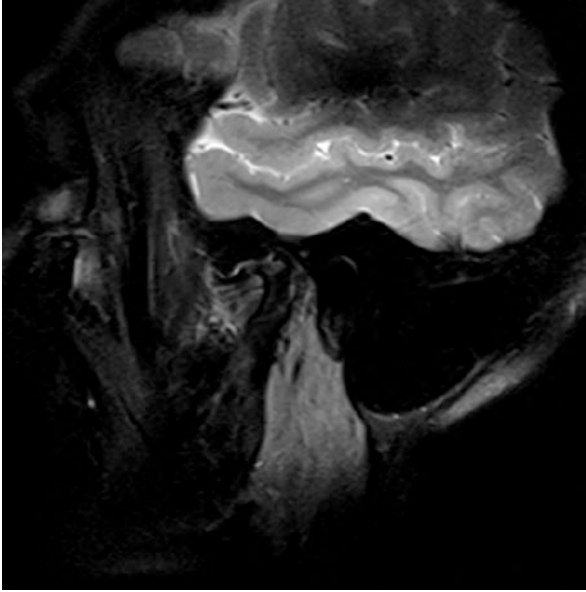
Osteoarthrosis no joint effusion T2-weighted MR
